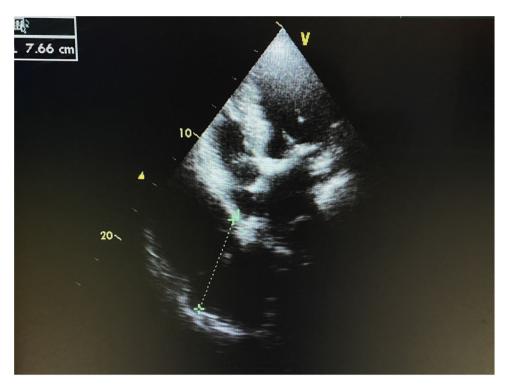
First transthoracic heart echocardiogram (parasternal long axis view) depicting an echolucent mass at the site of pericardium.
